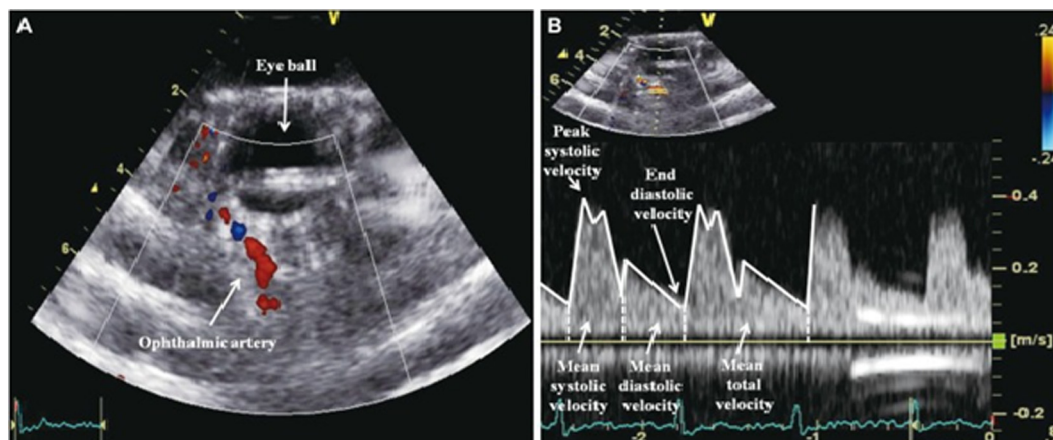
Colour Doppler imaging measures velocity in ophthalmic artery.
